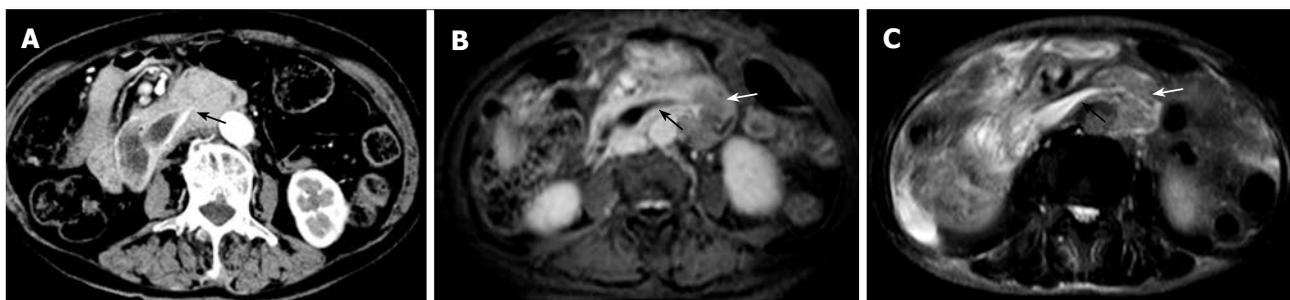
Anomalous termination of the common bile duct. A: Axial image from CT scan shows the termination of the common bile duct at the distal portion of the horizontal part of the duodenum (arrow); B and C: MR images demonstrate a tapered configuration of the common bile duct (black arrows) and a mass located on the proximal jejunum (white arrows). (These photographs were processed by Adobe Photoshop Creative Suite 2.).
